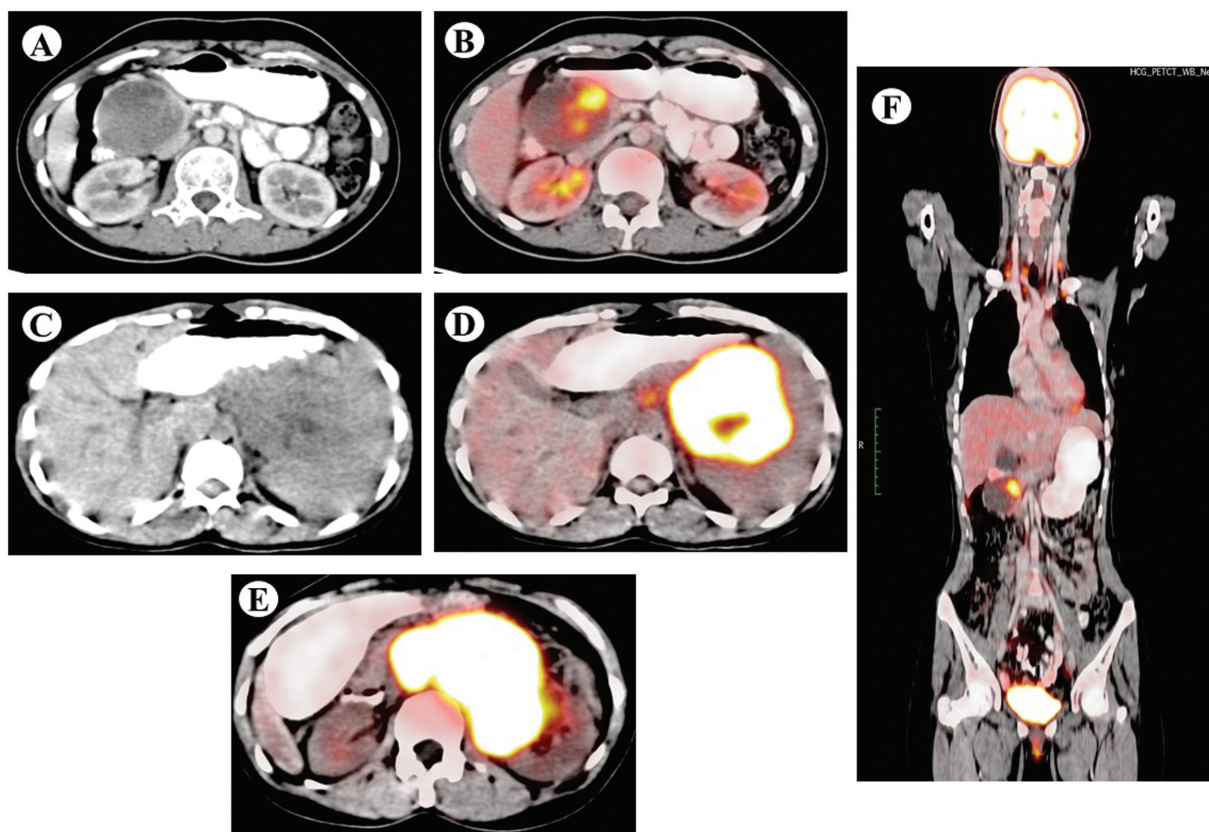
A and B: FDG avid mixed solid cystic lesion in head of pancreas. C and D: FDG avid mass in pancreatic tail infiltrating into splenic hilum. E: Large FDG avid mass in body and tail of pancreas. F: FDG avid mass in body of pancreas.
